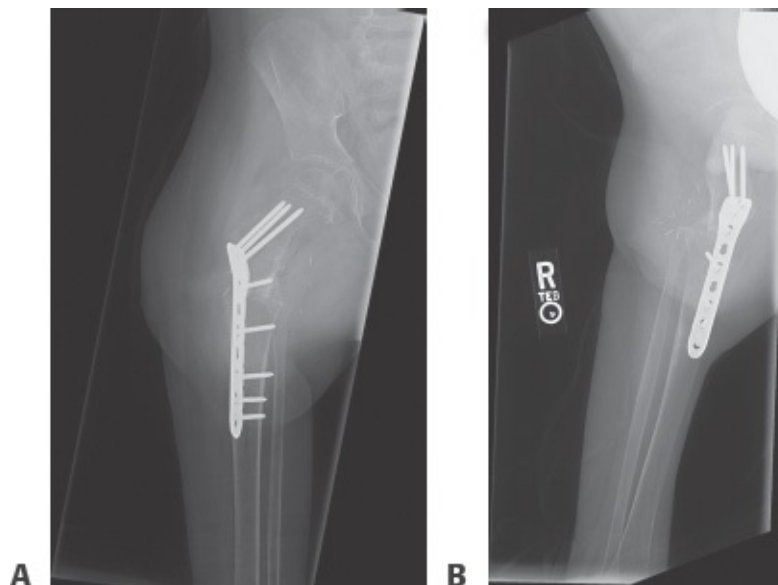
• Radiographs of the hip at 6 months postop. A. AP view. B. Lateral view.
